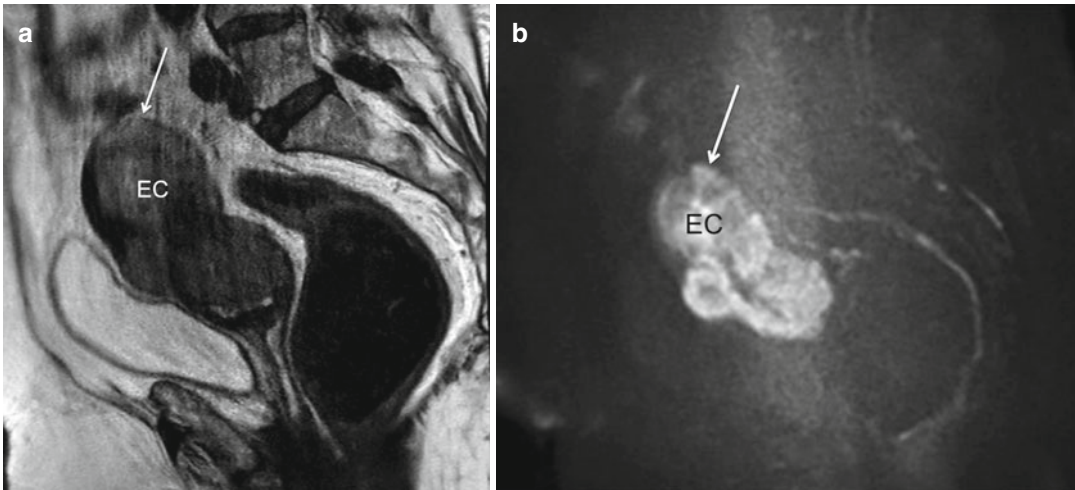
(a, b) Serosa infiltration (stage IIIA). Sagittal TSE T2-weighted image (TR/TE 2,400/76 ms) (a) shows a large endometrial carcinoma (EC) diffusely infiltrating the myometrium; of the uterine fundus and determining a
